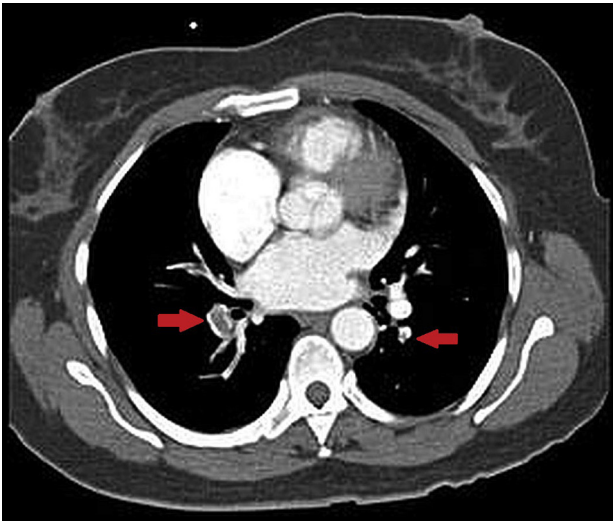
Contrast-enhanced CT scan showing bilateral pulmonary emboli.
